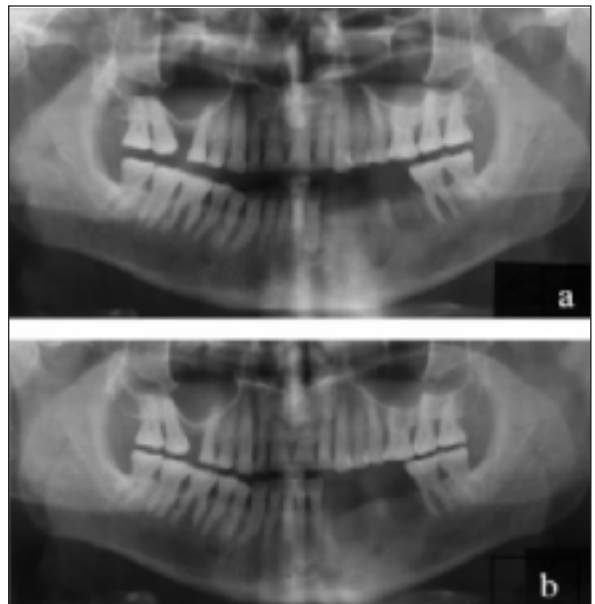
After the surgery (a) and 4 months later (b), in panoramic radiographs.
